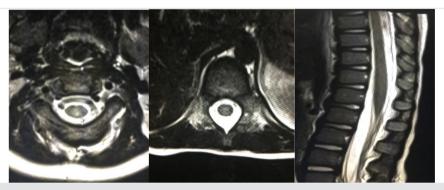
Spinal MRI shows LETM on cervical spinal cord, distal thoracic cord and conus levels MRI: Magnetic resonance imaging, LETM: Longitudinal extensive transverse myelitis
